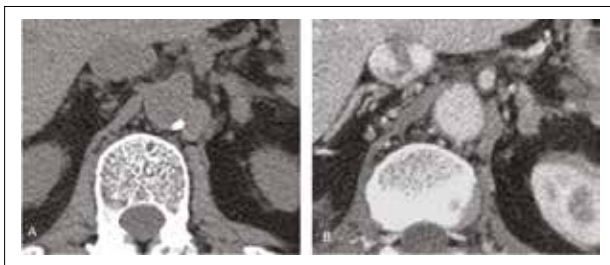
A 59-year-old man with lung cancer and left adrenal metastasis: (A) Axial unenhanced image showed a hypodense mass with attenuation of 39 HU (B) Axial post-contrast CT, this mass showed heterogeneous enhancement and diffuse infiltrative pattern involving medial limb and body of adrenal gland.
